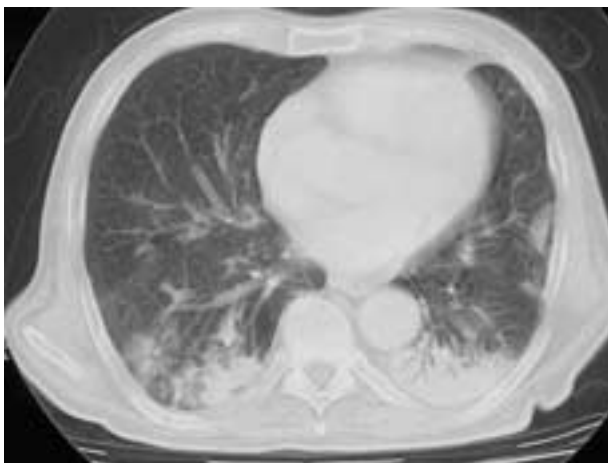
High-resolution computed tomography scan through the lower lobes: areas of alveolar opacification with air-bronchogram and ground glass attenuation are evident.
